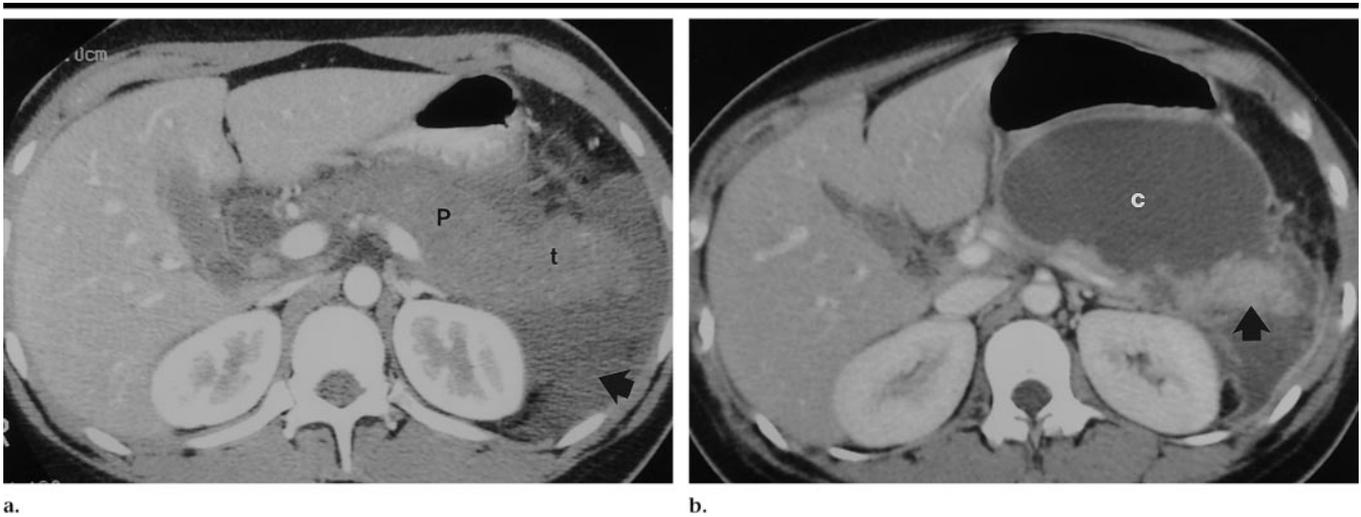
Acute pancreatitis in an 18-year-old woman with three Ranson grave signs. (a) Initial early transverse CT scan obtained with intravenous and oral contrast material reveals an enlarged low-attenuating (50–70-HU) pancreas (*P*), consistent with pancreatic ischemia and necrosis. Degree of necrosis is difficult to ascertain. A large fluid collection (arrow) is seen around the pancreatic body and tail (*t*). (b) Follow-up transverse CT scan obtained 14 days later reveals a fluid collection associated with liquified necrosis of most of the body of the pancreas, with the development of a pseudocyst (*c*). Note that the tail of the pancreas (arrow) is enhancing normally at this time.
